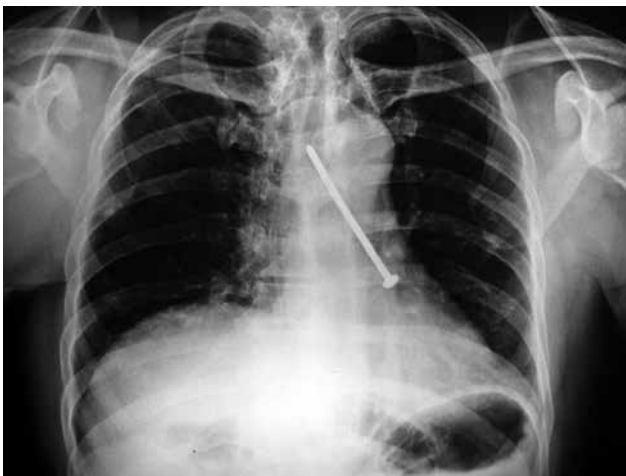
Image of the aspirated construction nail on posteroanterior chest X-ray.
